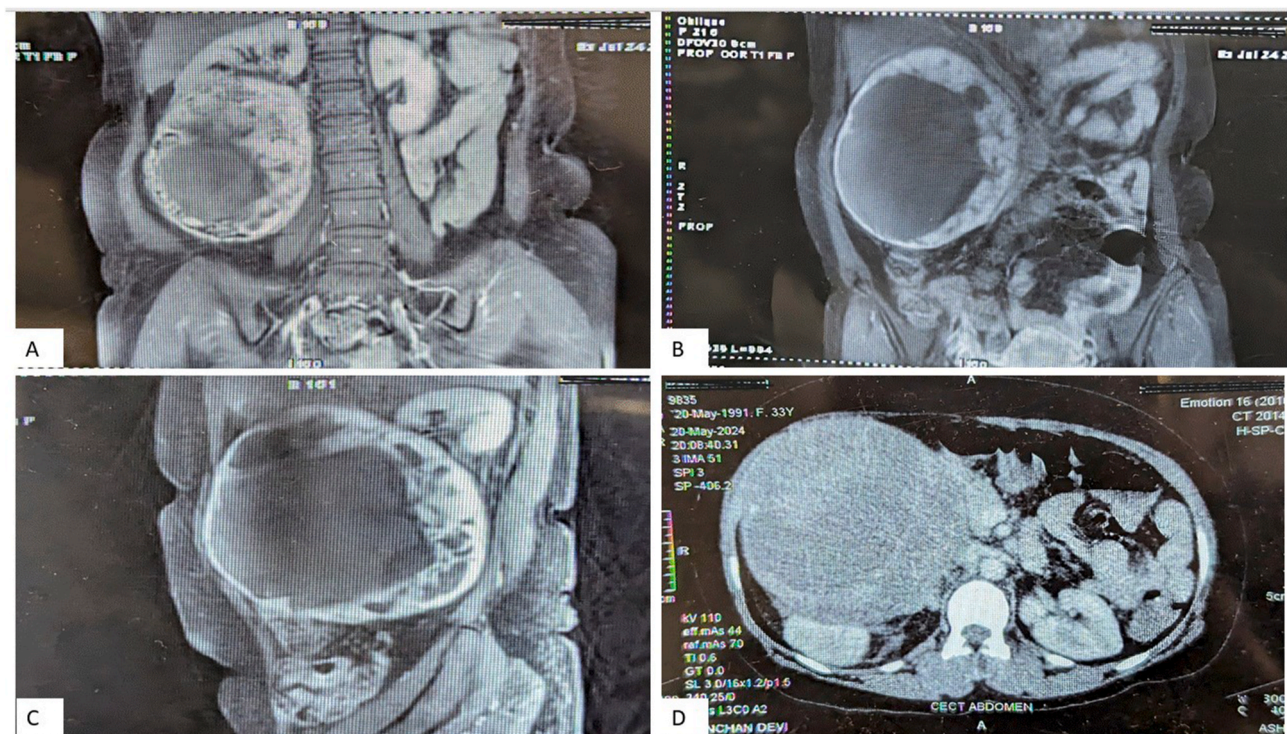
Radiological findings: CE-MRI (Figures A–C) and CECT (Figure D) revealing the presence of a large well defined, rounded, solid cystic mass lesion seen epicentered in the right lumbar region in the anterior pararenal space.
